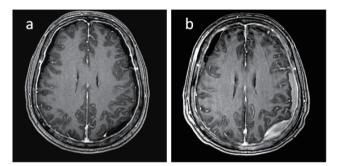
Comparison of T1-weighted brain MRI during admission (a) and one week after EBP treatment (b) showed disease progression. Both images show characteristics of SIH, including diffuse pachymeningeal enhancement and bilateral SDH.
